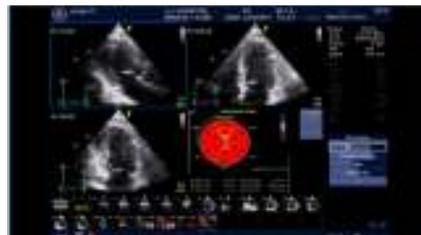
Apical, parasternal long axis, apical four chamber, apical two chamber view for speckled tracking analysis with strain
